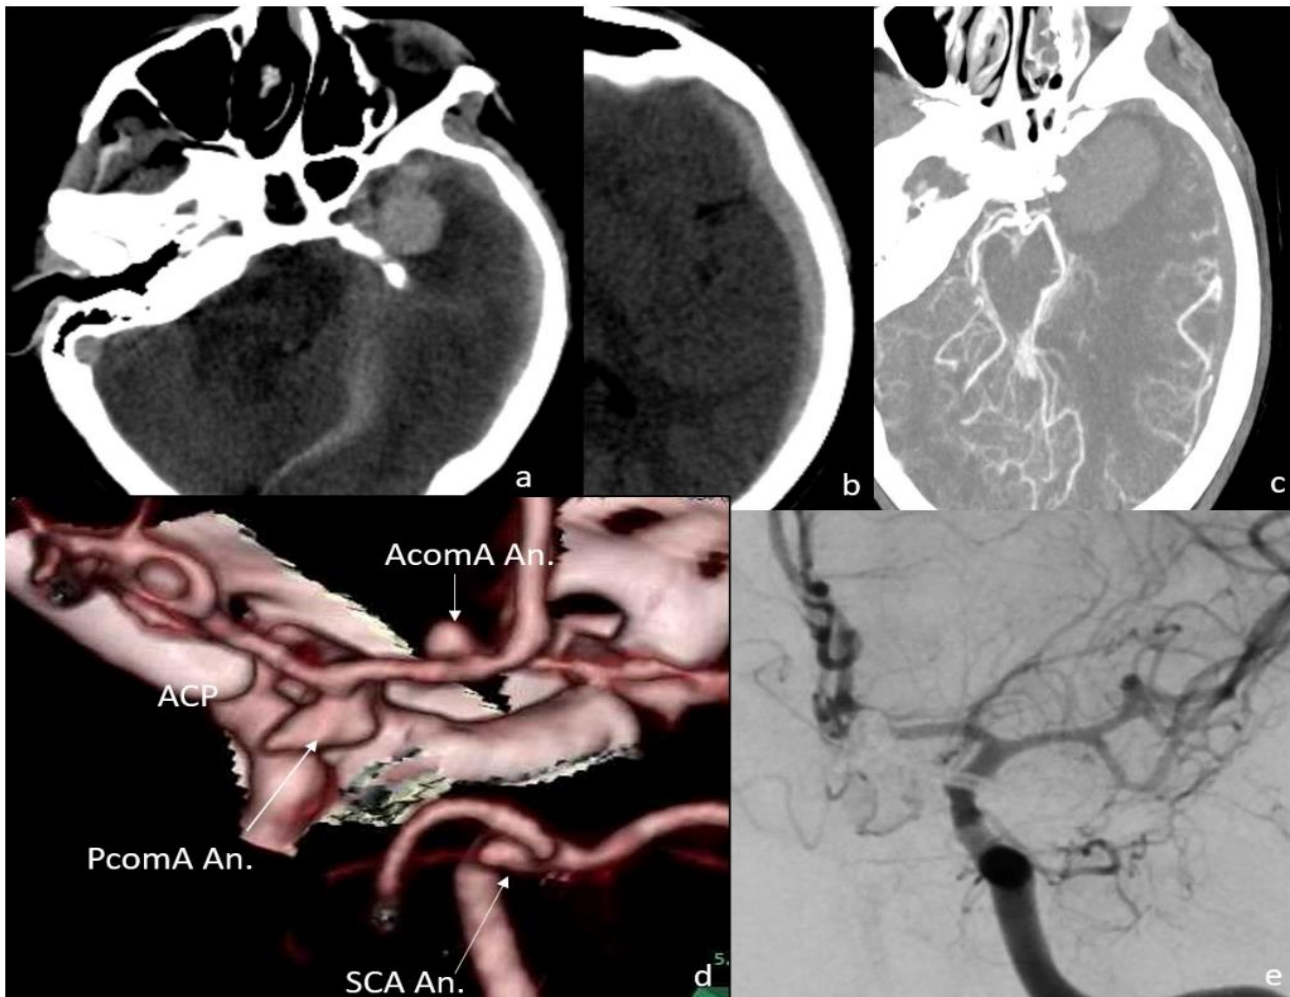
a,b) Computed tomography (CT) showing diffuse subarachnoid hemorrhage, intracerebral hematoma starting from the left temporal pole and extending to the convexity, and subdural hematoma, c,d) CT angiography revealed saccular aneurysms in the inferior laterally oriented posterior communicating artery (PComA), superior cerebellar artery (SCA), and anterior communicating artery (AComA), considering that the PComA aneurysm was bleeding, consistent with a hematoma, emergency surgery was performed, clip ligation of PComA and AComA aneurysms was performed in the same session, e) postoperative digital subtraction angiography image (patient number, 11)
